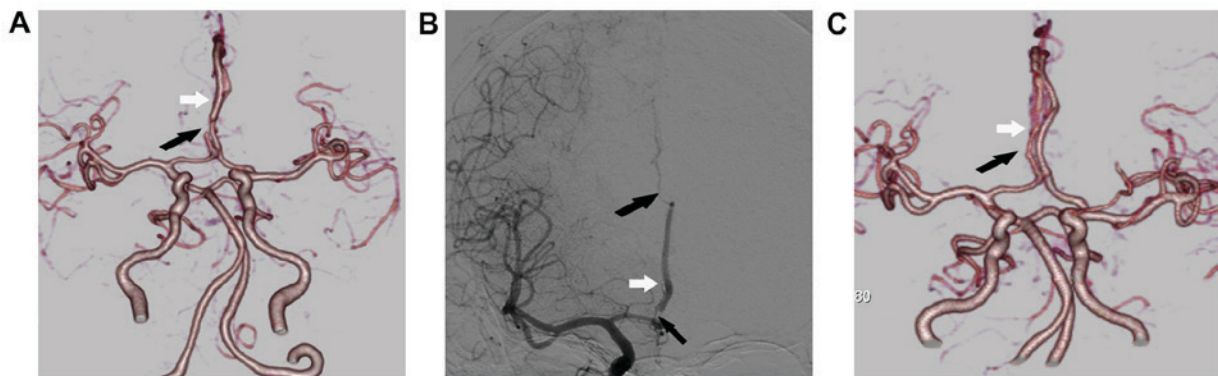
(A) CT angiography on day 5 after onset showed severe stenosis at the origin of the A2 segment (black arrow) with distal dilatation (white arrow) and occlusion at the origin of A3 segment of the right ACA. (B) Digital subtraction angiography on day 6 also showed severe stenosis at the origin of the A2 segment (black arrow) with distal dilatation (white arrow) and occlusion at the origin of the A3 segment of the right ACA (black arrow). (C) CT angiography after 5 months showed that the stenosis of A2 segment was considerably improved (black arrow) and the dilatation of A2 segment had almost disappeared (white arrow). CT, computed tomography; ACA, anterior cerebral artery.
